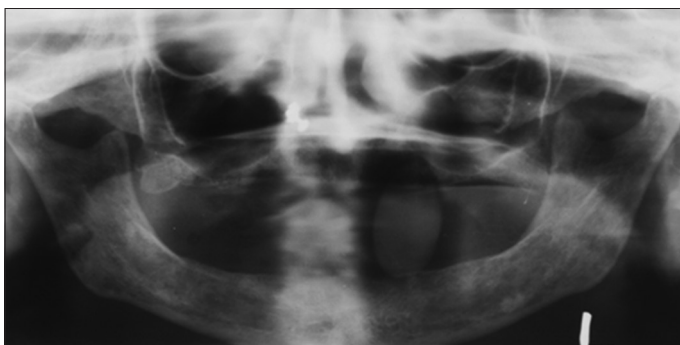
Orthopantomogram revealed completely edentulous with a well-defined, oval-shaped soft tissue shadow, approximately measuring 4 × 2 cm in relation to 22, 23, 33
